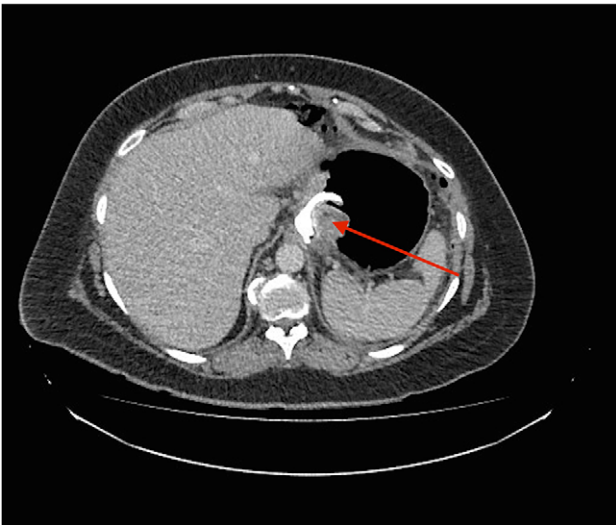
Cross section CT image demonstration the site of the band with no collection (red arrow).
